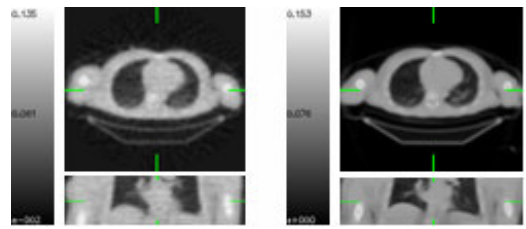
Axial and coronal views of the 23 min PET transmission scan (left). Axial and coronal views of the CT image interpolated to match the PET transmission scan (right).
